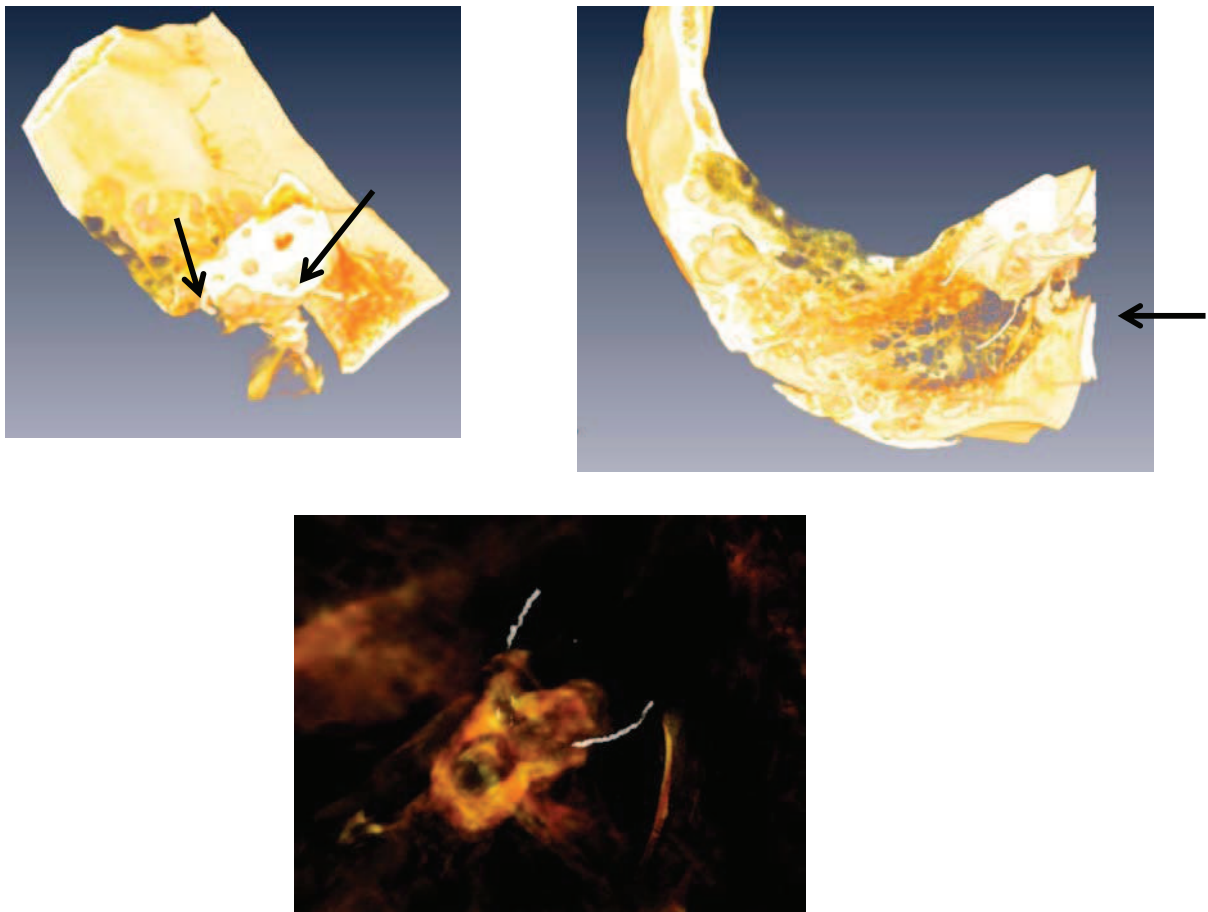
High resolution CBCT scan of a dry temporal bone with a vestibular implant. The arrows on the upper left image indicate the vestibular implant electrodes in the canals. The arrow on the upper right image marks the inner ear ossicles. On the lower image, the labyrinth with the electrodes is reconstructed as MIP image.
